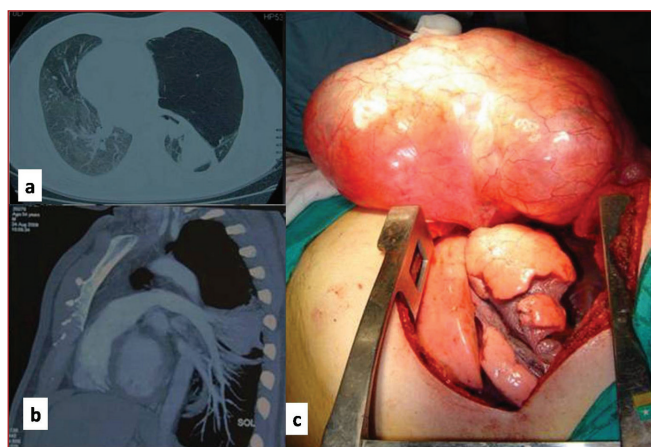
The appearance of the bullae and compressed lung on axial and sagittal plane on thorax CT and hypoplasia of the left upper lobe artery (a,b), intraoperative view of the bullae (c).
